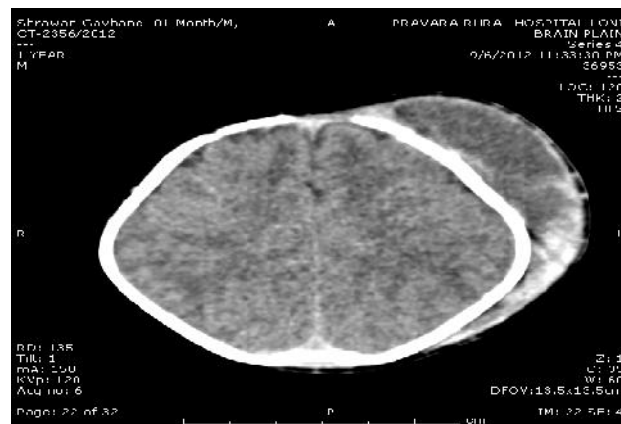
Contrast CT of brain
